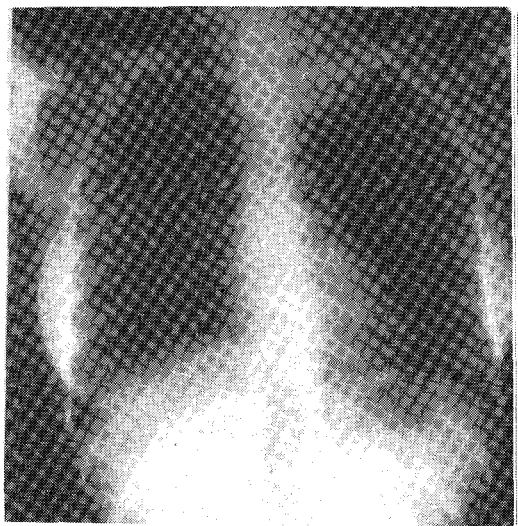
Plain chest X-ray of the patient showing a cervicomedial mass displacing the trachea to the right
